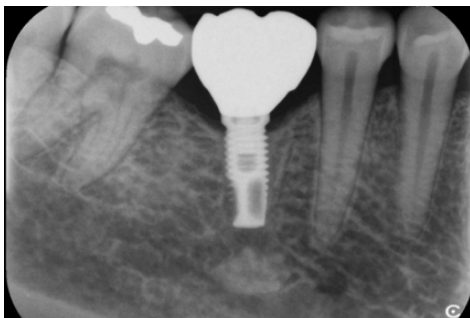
Radiograph (same case shown in Figure 1) 6 months after crown placement.
